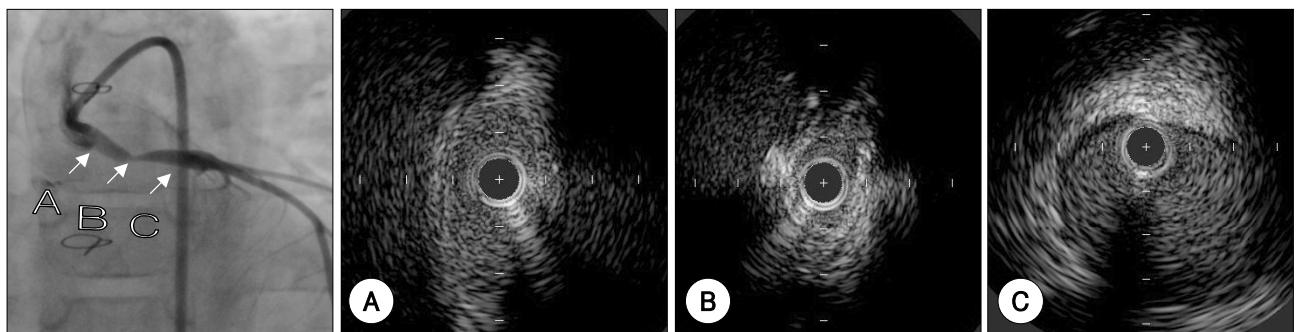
The coronary angiogram and intravascular ultrasound imaging prior to stent deployment. The arrows show the sites imaged, in cross section, using intravascular ultrasound imaging. Coronary angiography revealed anastomosis site stenosis between a proximal left subclavian artery free graft and the distal left main coronary artery. The proximal left subclavian artery free graft was elliptical (A), with a severely narrowed anastomosis site, but no atherosclerotic plaque was observed within the wall of the coronary artery; the left main coronary artery of the distal portion was normal (C).
